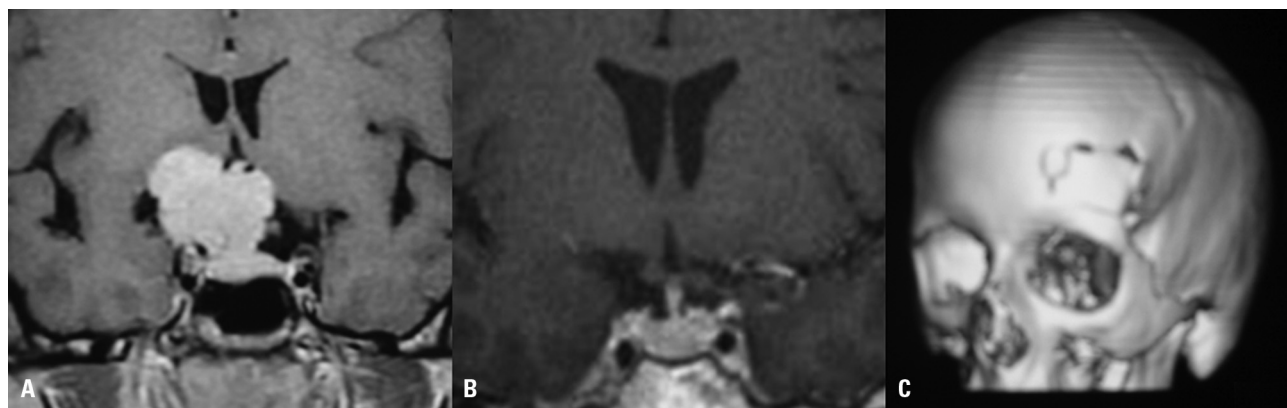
Coronal T1 MR with gadolinium showing a tuberculum sellae meningioma with partial encasement of the right carotid and anterior cerebral arteries [A]. Post operative MRI showing a total resection [B]. Cranial CT scan after reconstruction showing the craniotomy [C].
